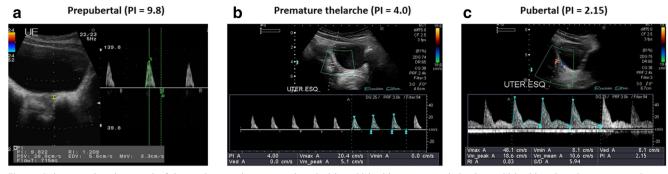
Color Doppler ultrasound of the uterine arteries. a Prepubertal girl. b Girl with premature thelarche. c Girl with pubertal response to GnRH stimulation test. GnRH, gonadotropin-releasing hormone. PI, pulsatility index. Courtesy of Iara Lucena, MD
